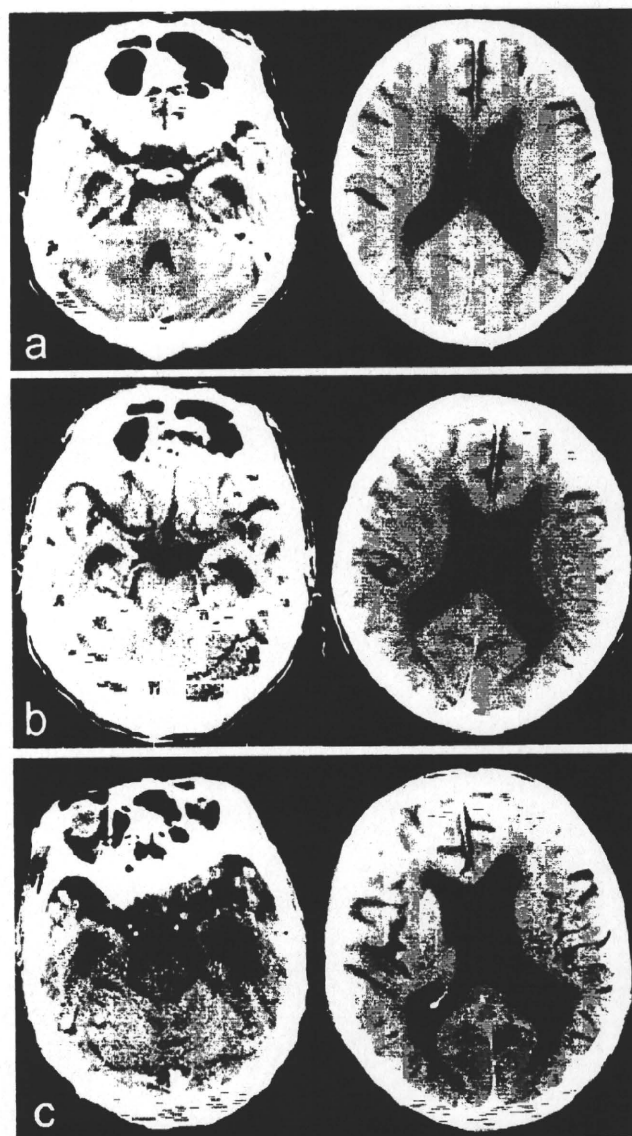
Computed tomography scans showing progressive enlargement of bilateral inferior ventricles. The temporal lobe showed progressive atrophy, whereas other cortical regions were relatively preserved in the course of the disease. Scans were taken (a) 3 years, (b) 5 years, and (c) 8 years (2 months before death) after the disease onset.
